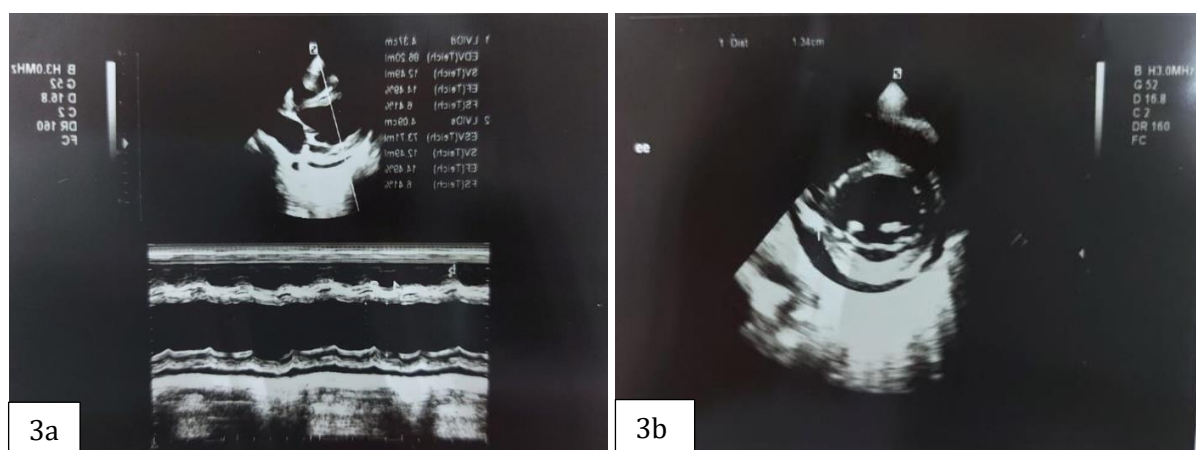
Echocardiography (a) reduced LV systolic function (b) minimal pericardial effusion
